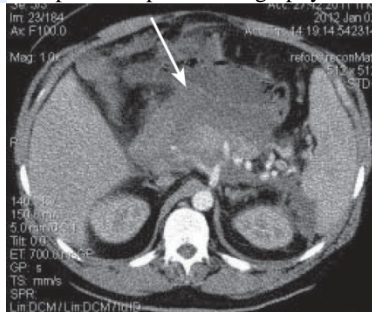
Spiral computed tomography of the abdomen. Retroperitoneal phlegmon
